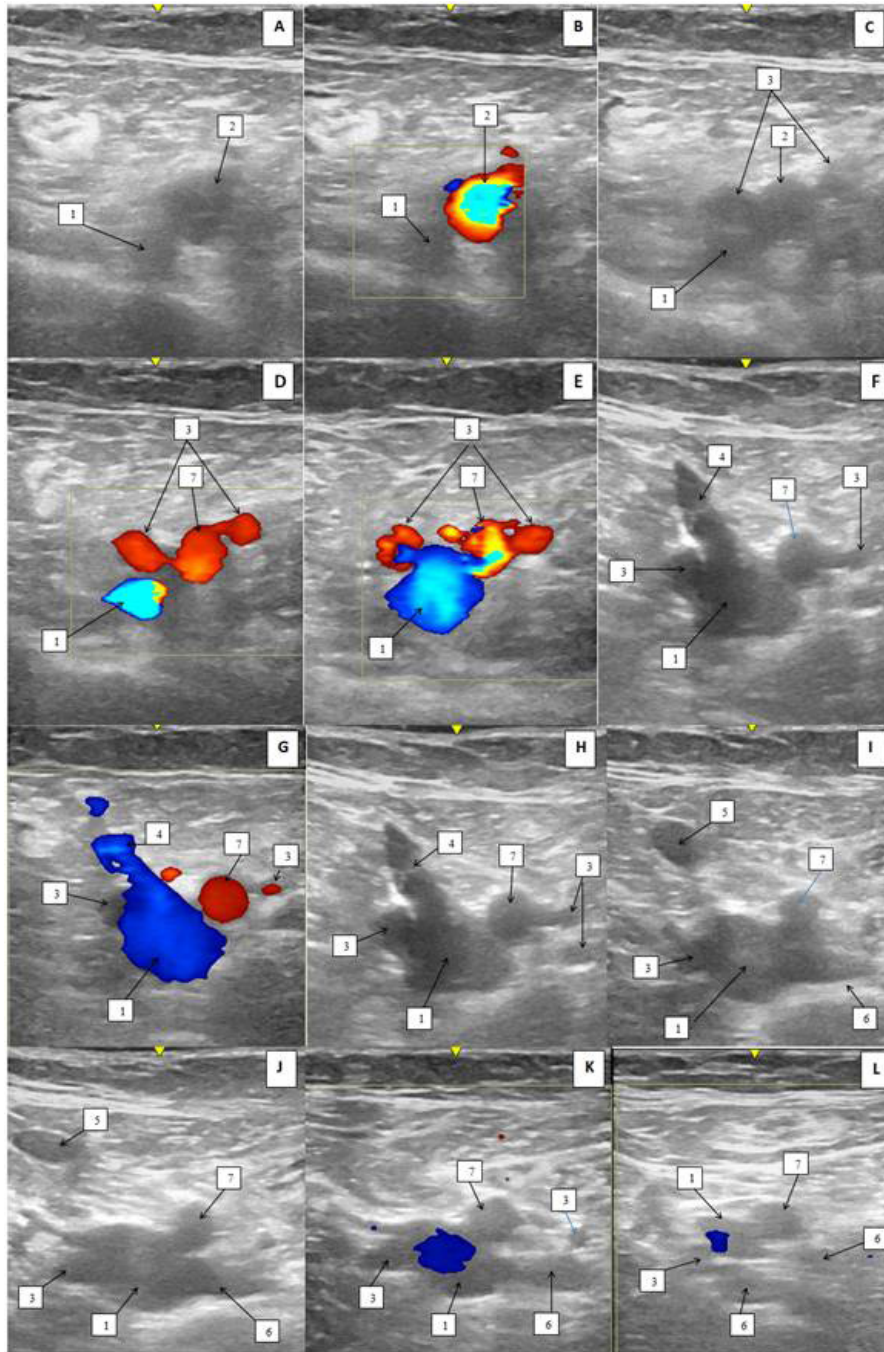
US duplex scan of the vessels of the upper third of thigh on the left of patient K. (two-dimensional, gray scale mode (B-mode) and color Doppler imaging mode; cross-section): (A–E) superiorly the saphenofemoral junction; (F–H) the level of saphenofemoral junction; (I–L) — inferiorly the saphenofemoral junction.
